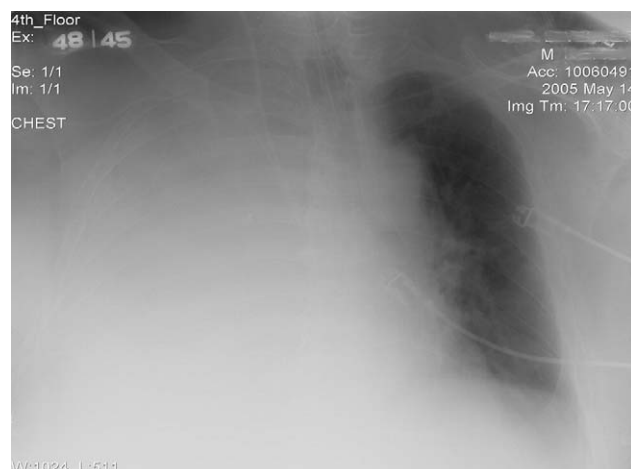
A chest roentgenogram demonstrating complete filling of the right hemithorax with a tracheal shift to the left.
